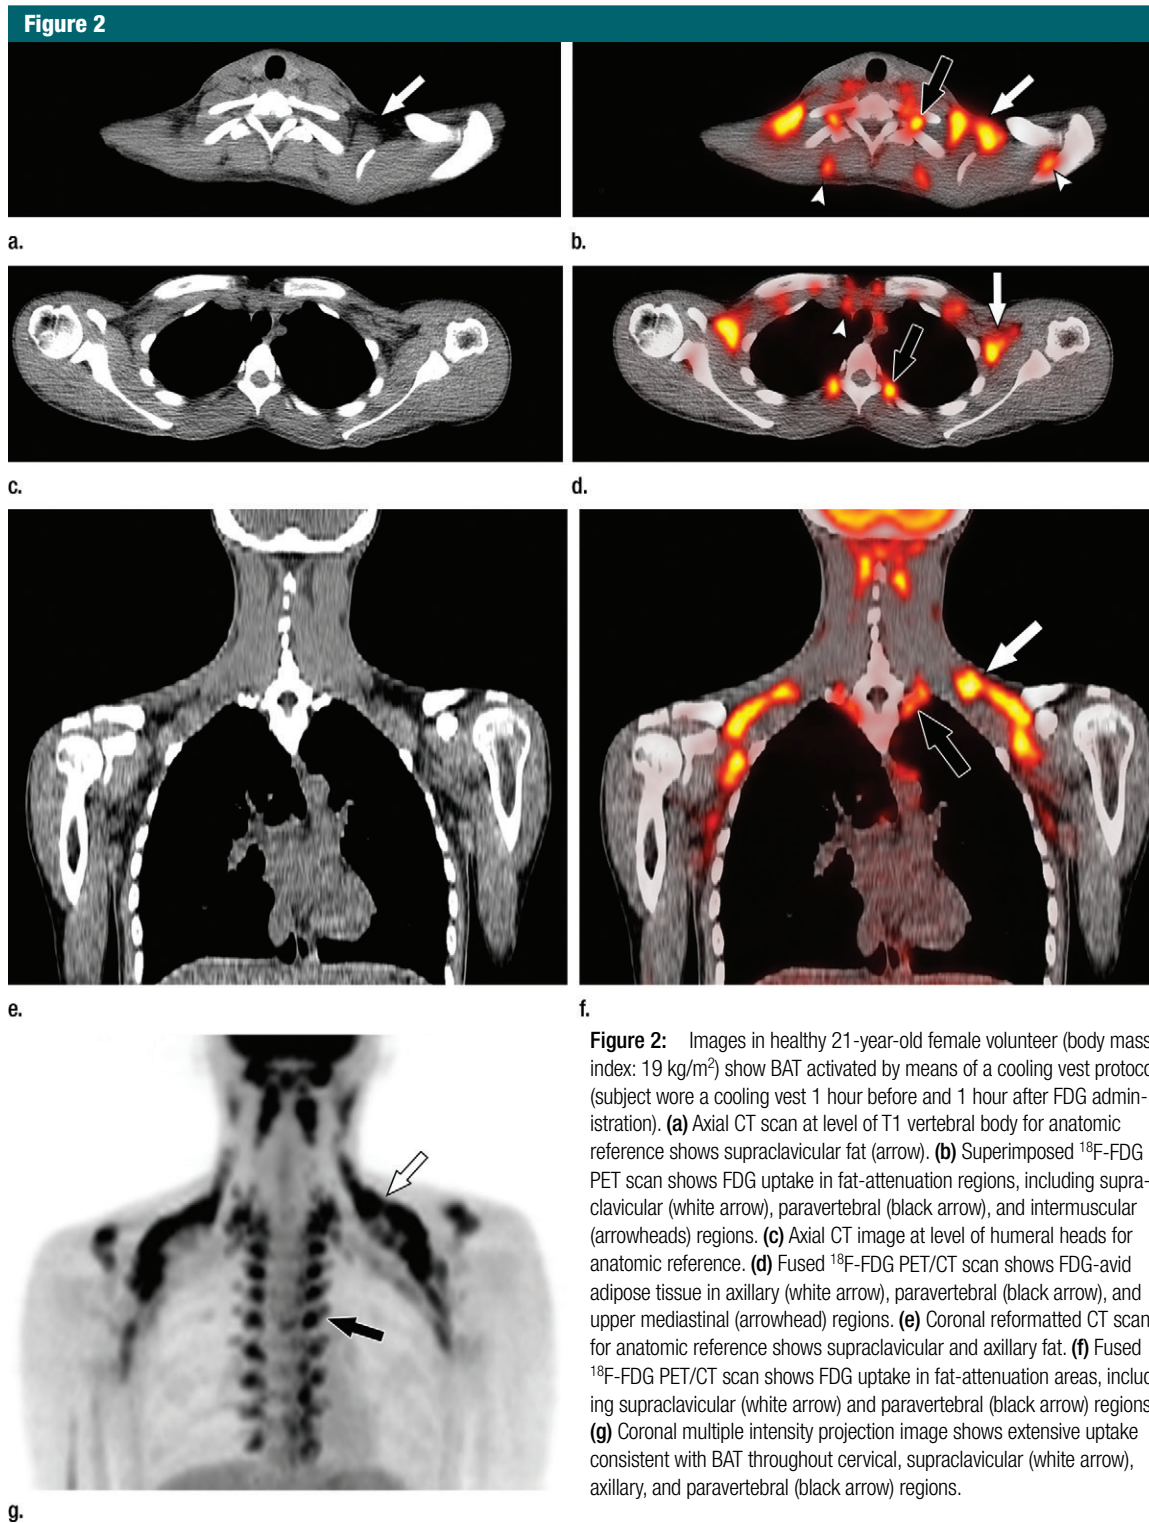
Images in healthy 21-year-old female volunteer (body mass index: 19 kg/m²) show BAT activated by means of a cooling vest protocol (subject wore a cooling vest 1 hour before and 1 hour after FDG administration). (a) Axial CT scan at level of T1 vertebral body for anatomic reference shows supraclavicular fat (arrow). (b) Superimposed ^{18}F -FDG PET scan shows FDG uptake in fat-attenuation regions, including supraclavicular (white arrow), paravertebral (black arrow), and intermuscular (arrowheads) regions. (c) Axial CT image at level of humeral heads for anatomic reference. (d) Fused ^{18}F -FDG PET/CT scan shows FDG-avid adipose tissue in axillary (white arrow), paravertebral (black arrow), and upper mediastinal (arrowhead) regions. (e) Coronal reformatted CT scan for anatomic reference shows supraclavicular and axillary fat. (f) Fused ^{18}F -FDG PET/CT scan shows FDG uptake in fat-attenuation areas, including supraclavicular (white arrow) and paravertebral (black arrow) regions. (g) Coronal multiple intensity projection image shows extensive uptake consistent with BAT throughout cervical, supraclavicular (white arrow), axillary, and paravertebral (black arrow) regions.
